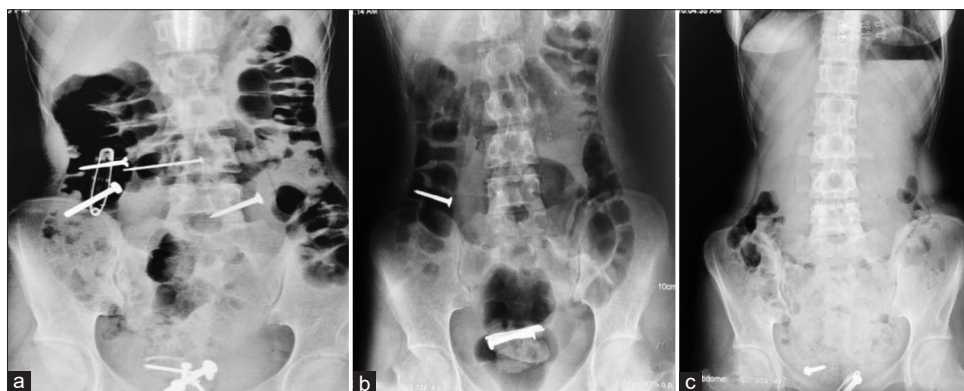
Abdominal radiograph at (a) presentation, (b) after 24 h and (c) 48 h of admission (case 1)
